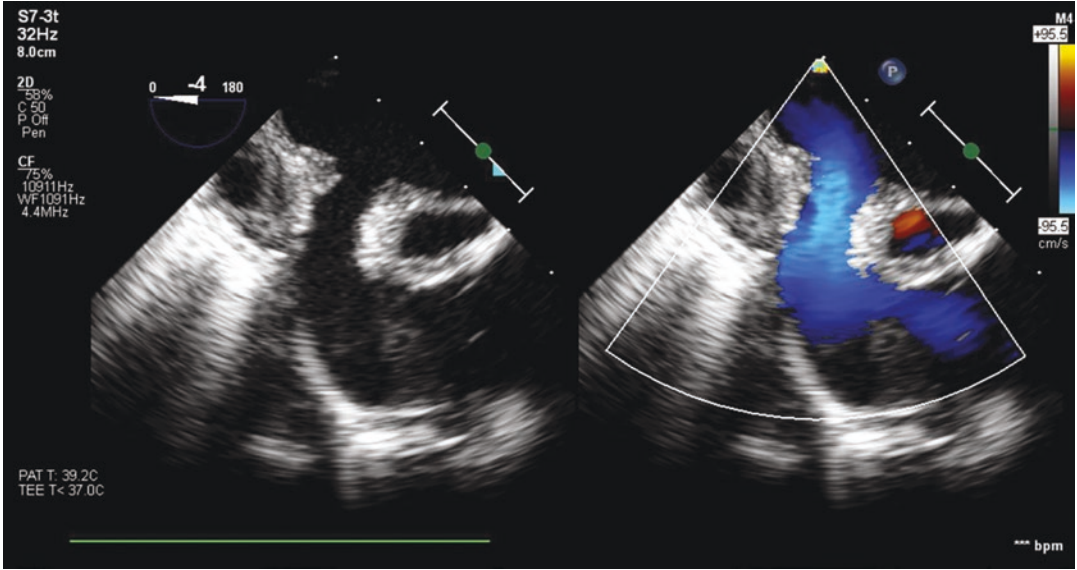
Postoperative TEE demonstrating patency and flow in the pulmonary venous baffle. By 2D and color Doppler mapping, the pathway appears widely patent with low velocity, non-aliasing antegrade flow, directed toward tricuspid valve and systemic right ventricle
